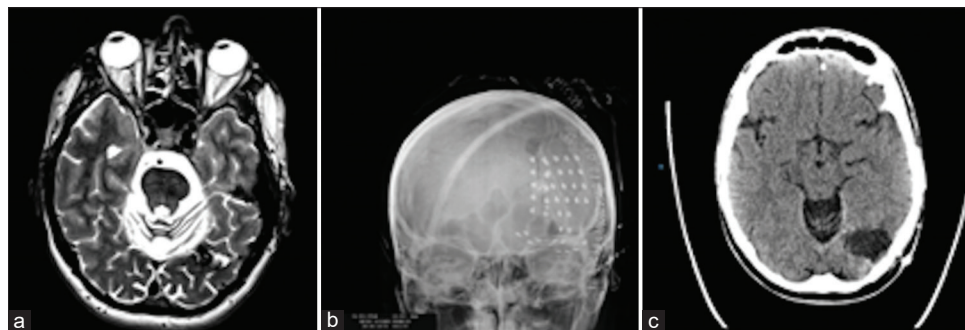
Forty-year-old patient with epilepsy for 16 years consisting of simple, complex, and secondarily generalized partial seizures with visual aura. (a) Axial presurgical brain magnetic resonance imaging scan showing an arteriovenous malformation treated with embolization in the left occipital region. (b) Simple skull radiograph showing the arrangement of the subdural grid electrode. (c) Axial postsurgical cranial CT scan showing a left occipital lesionectomy. After surgery, the patient rarely presents crisis (Engel Class II). Postoperatively, he had an absolute scotoma with slight respect of the central area.
